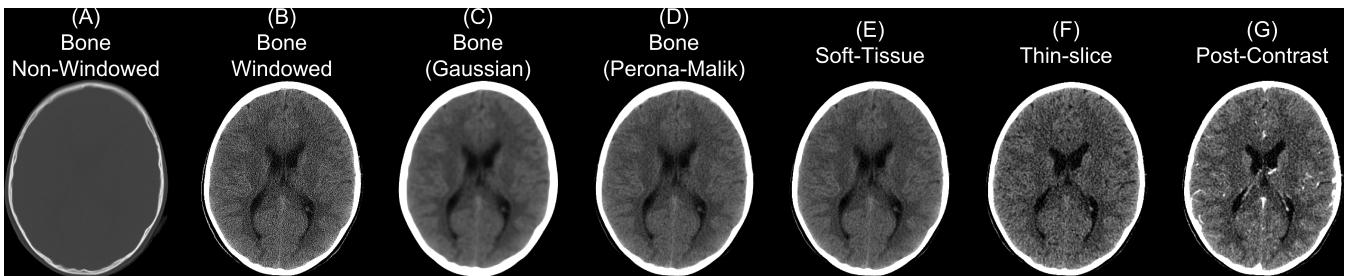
Different Series for a Scanning Study. Here we present different non-contrast head CT exported from a PACS. We display a reconstructed scan with a bone convolution kernel (A), showing bright areas of the skull, which can be investigated for breaks or fractures. When applying a window of 0 - 100 Hounsfield units (HU) of this image, we see the image resolution (B). Using a Gaussian (C) or Perona-Malik (D) smoother, we see we get smoother images, similar to the image reconstructed with a soft-tissue convolution kernel (E). Images (A-E) had a slice thickness of 5mm. The thin-slice scan (F) had a slice thickness of 0.62mm and a soft-tissue convolution kernel.
